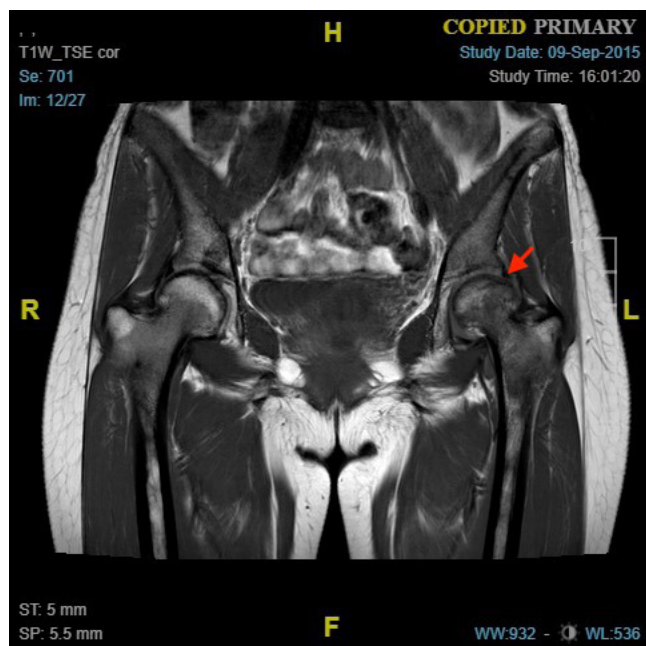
T1 weighted image of MRI which shows focal area of hyperintense with hypointense rim at the left head of femur.
